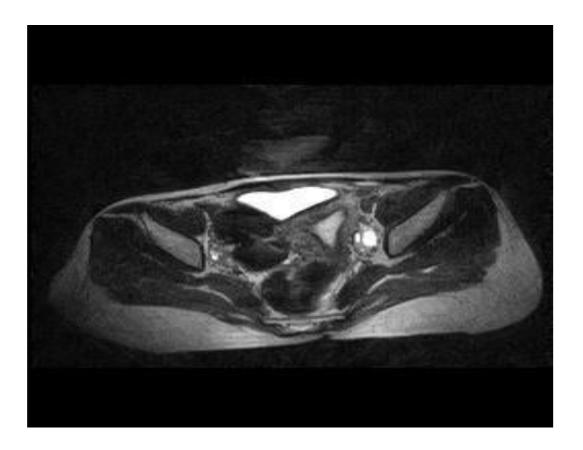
MRI T2w image coronal section demonstrates Bicornuate uterus.
